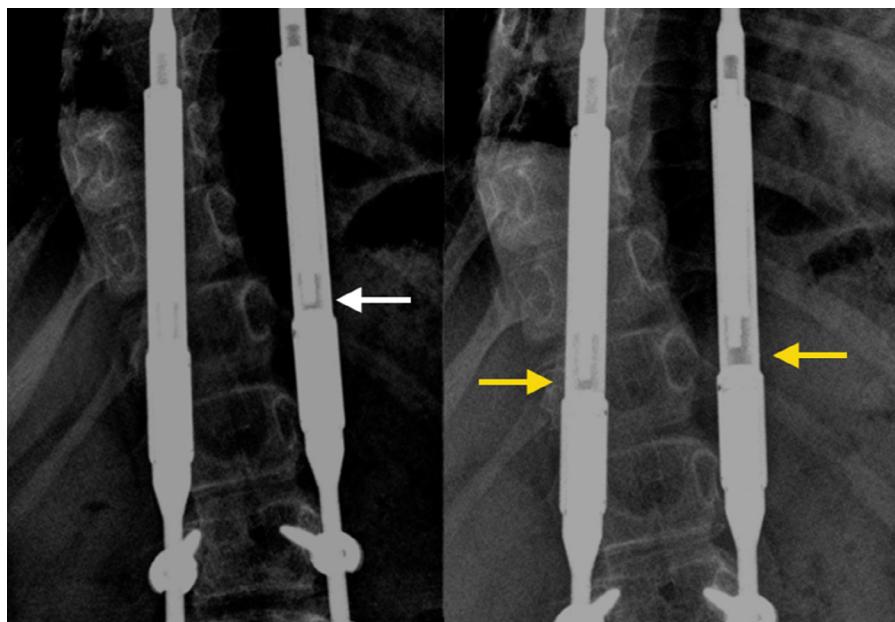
Anteroposterior radiographs of second patient, taken at intervals every 6 months, demonstrating progression of pin breakage from (Left) left only (white arrow) to (Right) bilateral (yellow arrows).
